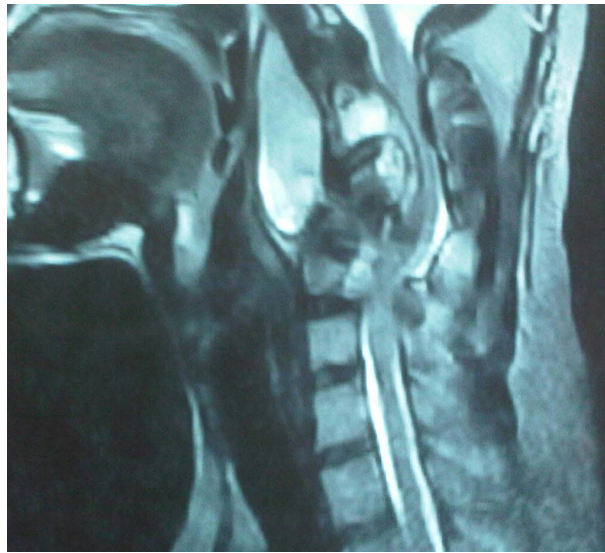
Magnetic Resonance Imaging scan of the patient's cervical spine showing a retropharyngeal prevertebral collection, C3 to C5 vertebral body destruction and local kyphosis.
